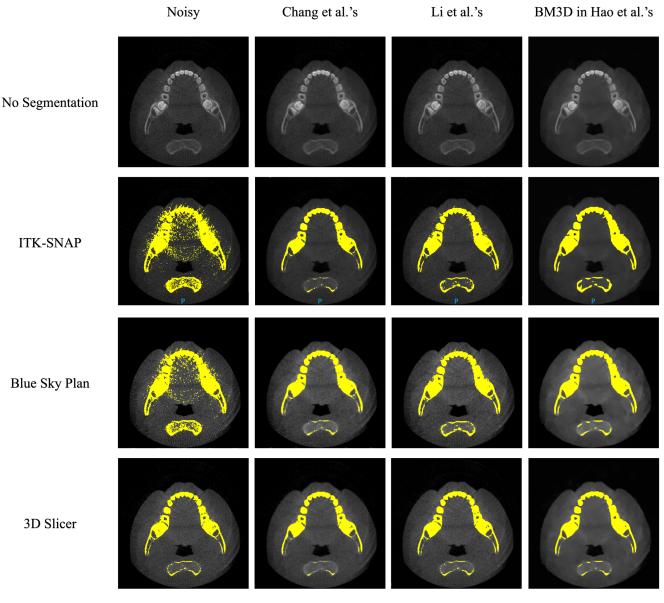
Results of the different segmentation methods on noisy and denoised CBCT images.
